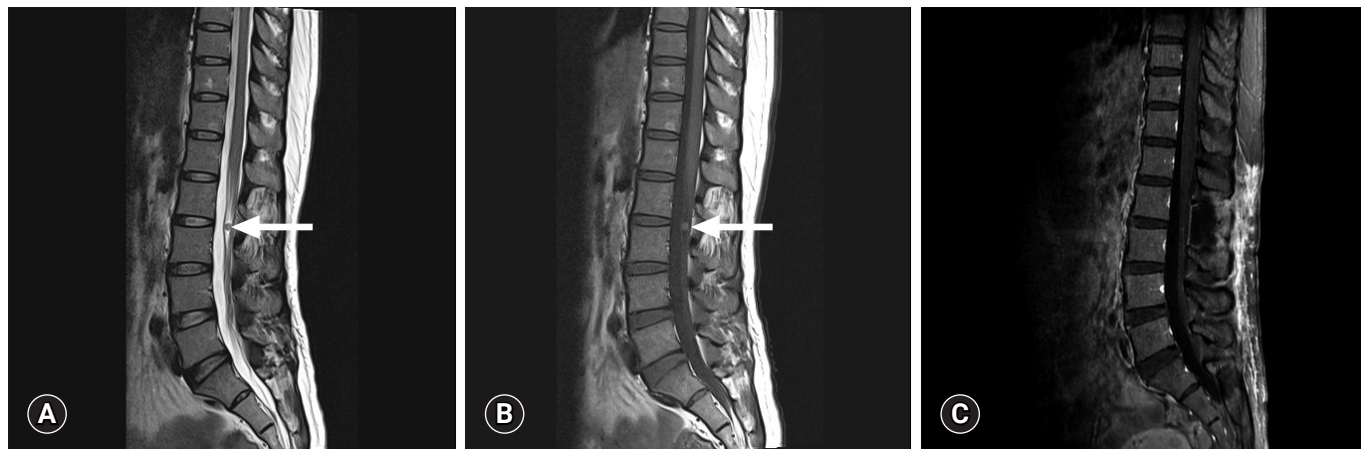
Magnetic resonance imaging (MRI) findings. (A) Sagittal T2-weighted MR image of the lumbar spine showing a well-demarcated low-to-intermediate signal mass at lumbar level 2-3 spine (arrow). (B) Sagittal T1-weighted image showing high signal intensity (arrow). (C) No evidence of recurrence is visible in follow-up T1-weighted enhanced MRI.
